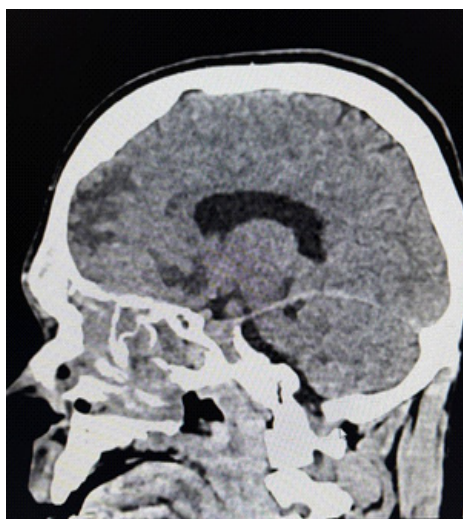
Sagittal CT scan of the brain and paranasal sinuses showing a large ethmoid-centered mass with anterior cranial fossa extension.
